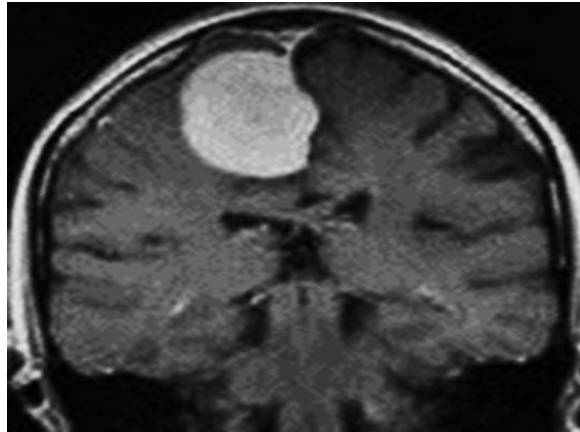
MRI of falx meningioma
